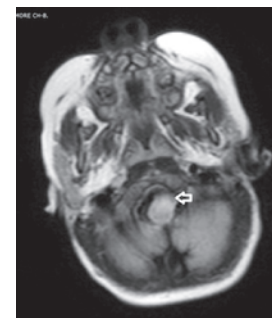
CT brain - Cervical cord
